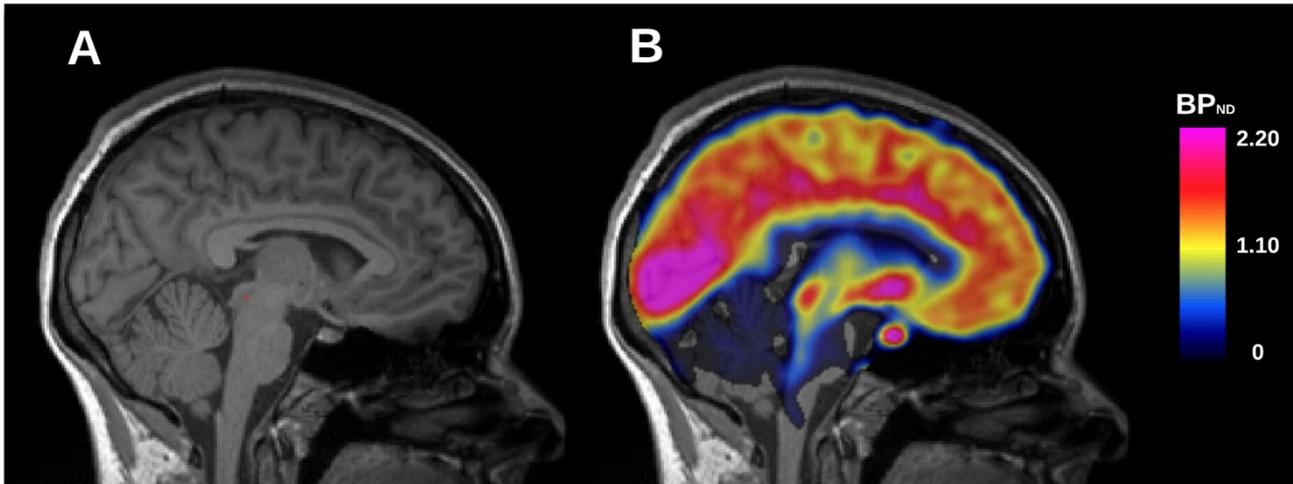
An example of a parametric BP_{ND} map. A. A structural T1-weighted MRI image from a single subject. B. Parametric BP_{ND} maps of [^{11}C]AZ10419369 superimposed on the corresponding structural image, highlighting the 5-HT_{1B} system.
